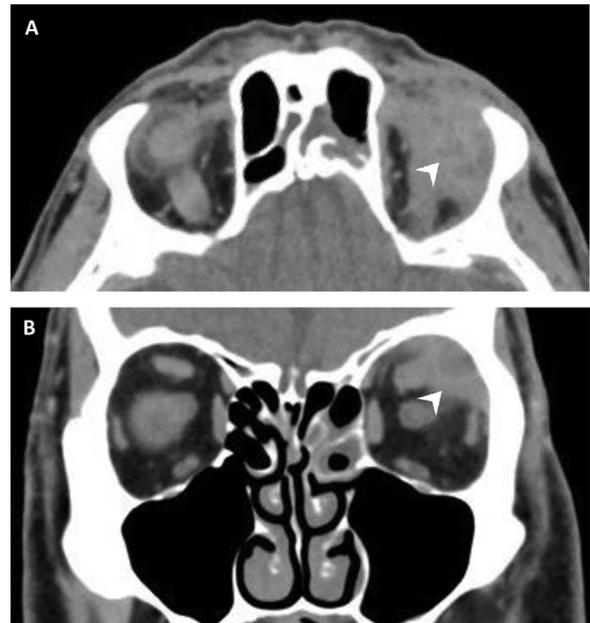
Computed tomography scans showing a left superolateral orbital lesion (arrowheads). (A) Axial image showing heterogeneous mass in left lateral orbit. (B) Coronal image showing superolateral orbital mass with hypodensity peripherally, correlating with an area of abscess.
